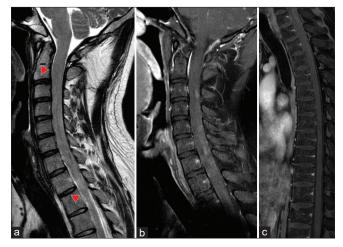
Preoperative gadolinium contrast-enhanced magnetic resonance imaging images of the spinal cord. (a) T2-weighted sagittal image. Spinal cord enlargement is seen from C2 to Th2 levels (red arrowhead), with no spinal fluid cavity signal identified. (b and c) Sagittal T1-weighted images of the whole spinal cord with gadolinium contrast enhancement. Diffuse patchy enhancement is evident.
